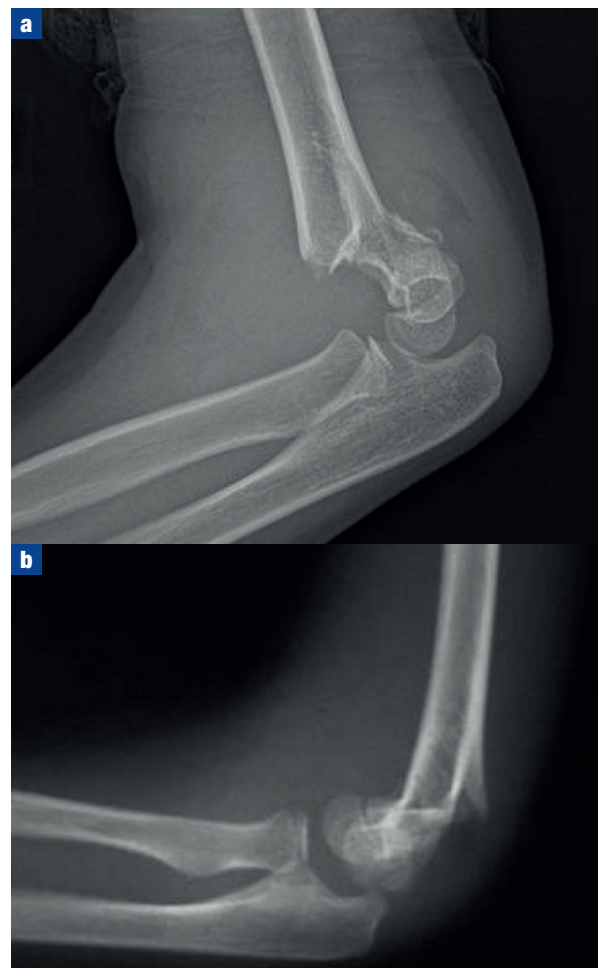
a. Lateral radiograph of the elbow in a extension-type supracondylar fracture. b. Lateral radiograph of the elbow in a flexion-type supracondylar fracture.
